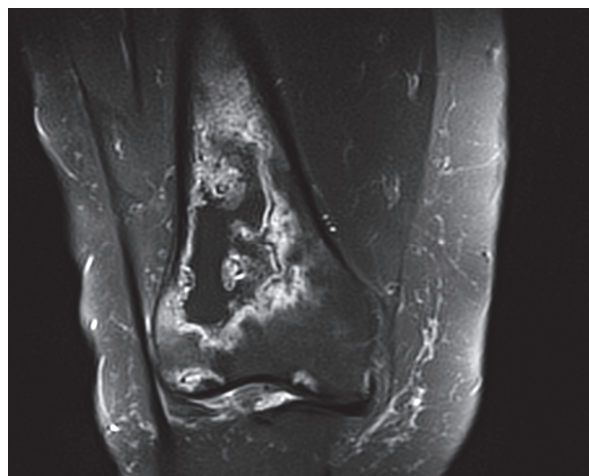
Knee osteonecrosis on sagittal T2-weighted images after intraarticular corticosteroid and local anesthetic injection.
